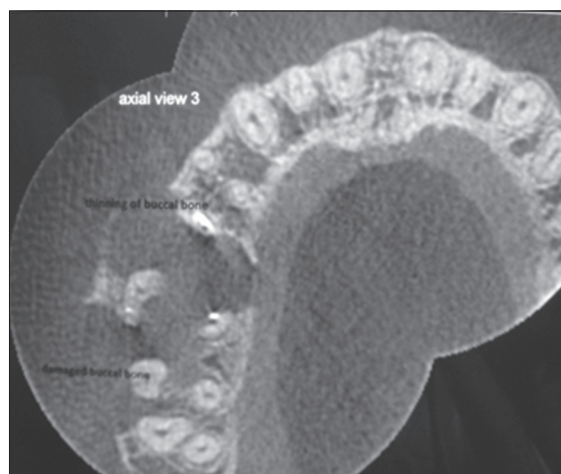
Axial view computed tomography scan depicting buccal and lingual cortical expansion with resorption
